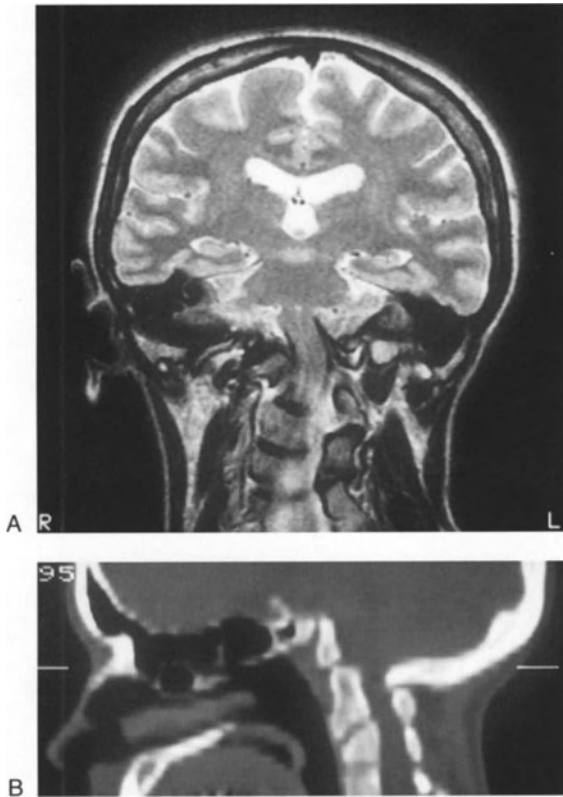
Basilar impression. In (A), the coronal T2 weighted image, one sees moderate ventriculomegaly, marked pooling of cerebrospinal fluid in the cortical sulci and curvilinear distortion of the pontomedullary portions of the brainstem. (B) This sagittal CT reconstruct reveals the typical components of basilar impression and the narrowing they impose upon the foramen magnum.
